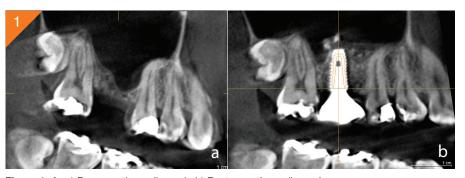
a) Pre-operative radiograph. b) Post-operative radiograph.
